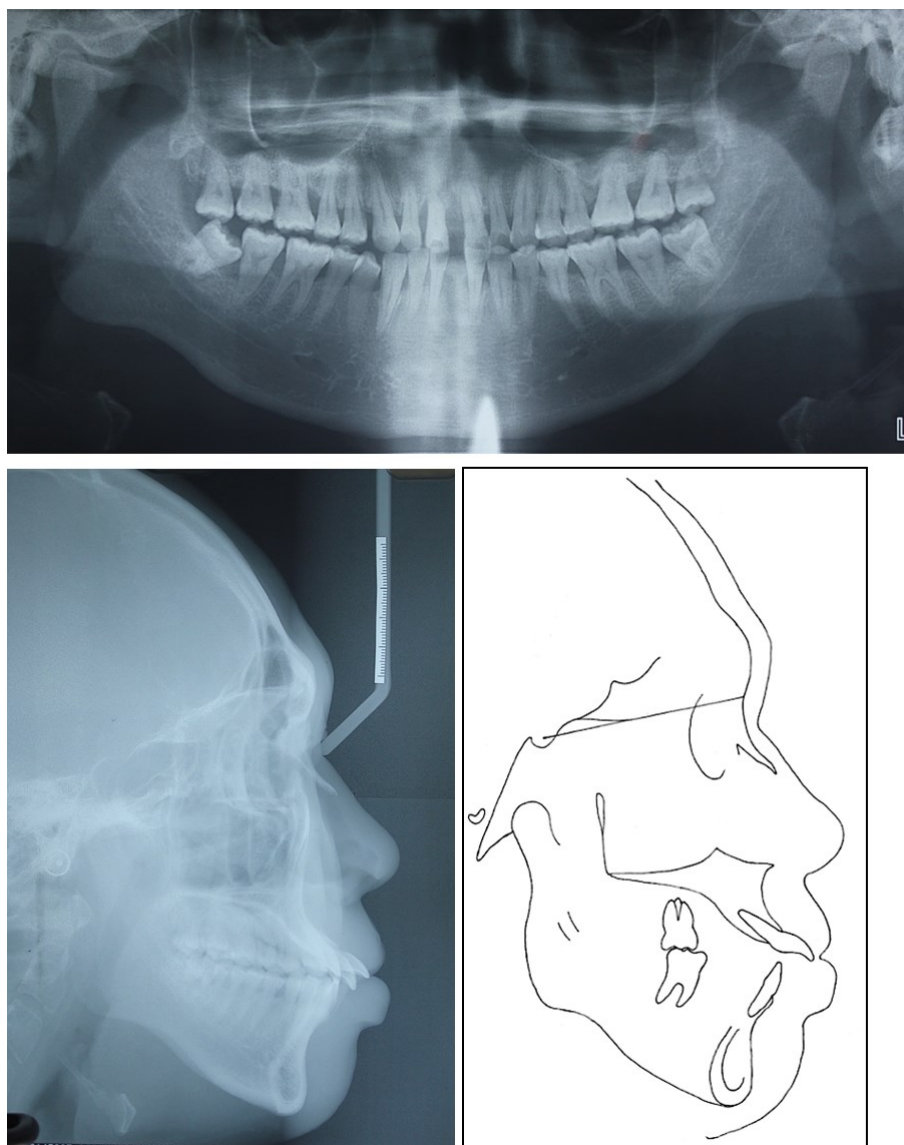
Pre-treatment panoramic radiograph and lateral cephalometric radiograph and tracing.
